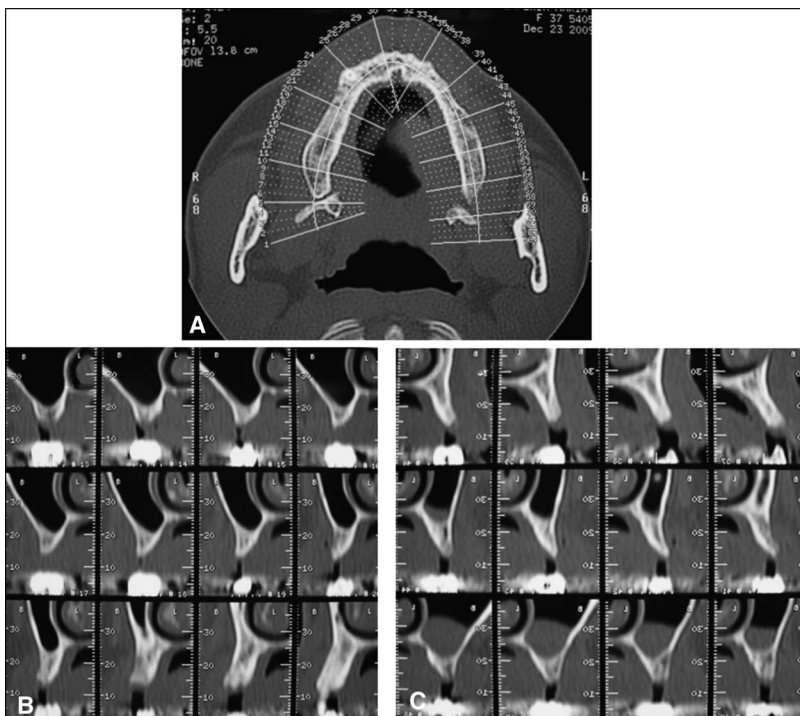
A–C, Presurgical CT scans.
